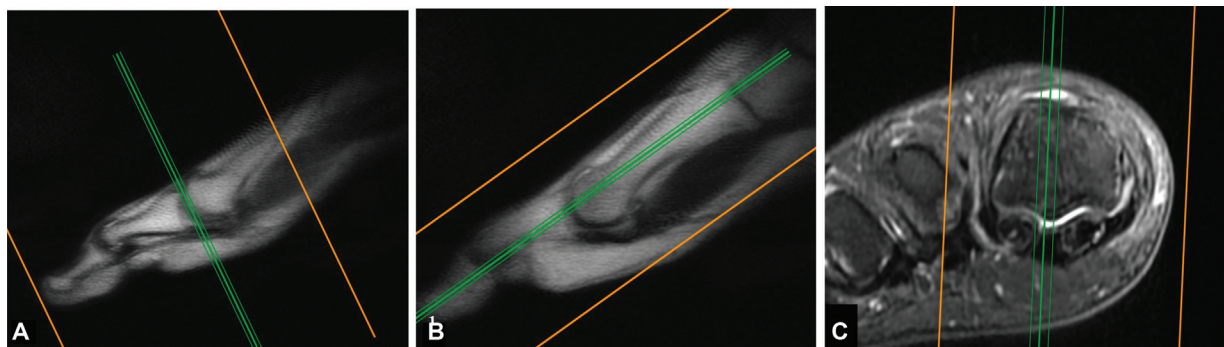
Planning of magnetic resonance imaging great toe. (A) First, the localizer was used to plan axial images perpendicular to the long axis of the metatarsal and proximal phalanx. (B) The coronal slices were planned on the sagittal plane, parallel to the to the long axis of the metatarsal and proximal phalanx. (C) Using axial images, sagittal scan was planned perpendicular to the line joining the two sesamoids.
